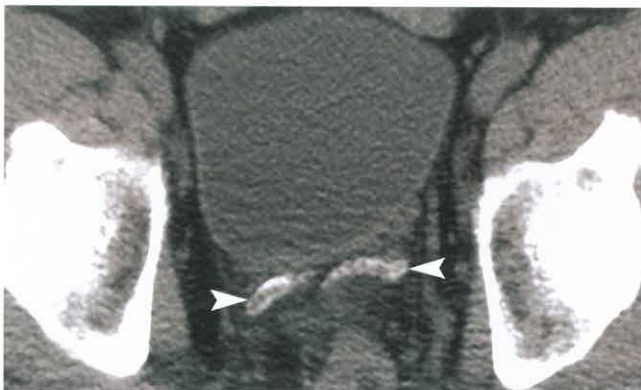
Calcification of the Vas Deferens. CT without contrast shows calcification of the bilateral vas deferens (arrowheads). This finding is almost universally associated with the presence of diabetes mellitus.
